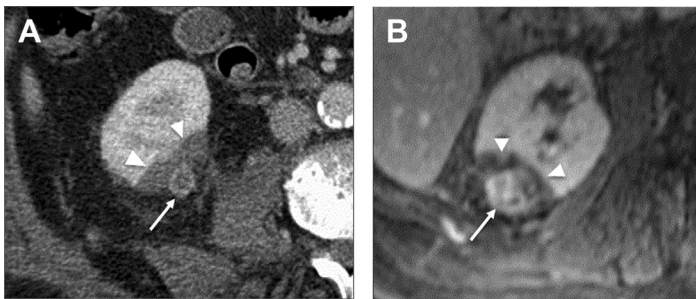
Early postablation enhancement in 2 patients. (A) CT image obtained 1 day after ablation shows small rounded focus of enhancement (*arrow*) within ablation zone (*arrowheads*). (B) MR image obtained 1 day after ablation shows large rounded focus of enhancement (*arrow*) within ablation zone (*arrowheads*).
